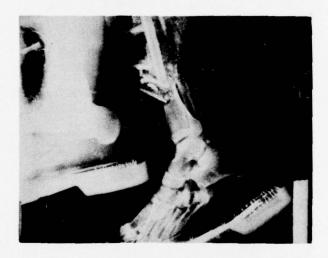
Roentgenogram showing extensive fractures of the tibia and fibula. (AFIP Neg. 73-4261-4.)
